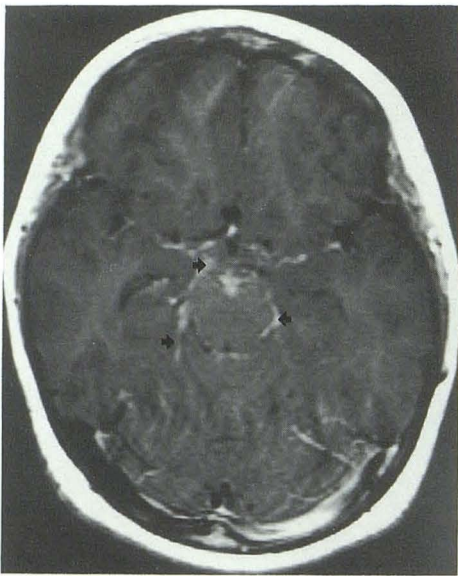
Patient 2. Boy age 5 with meningeal enhancement after 1 year intrathecal therapy (arrows); T1-weighted (500/15) axial image. CSF cell counts indicated ongoing active disease.
